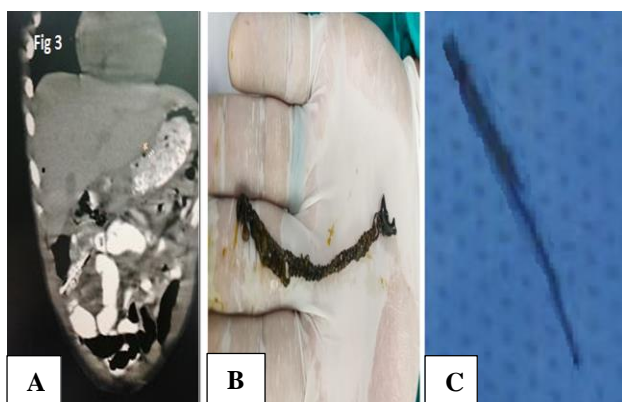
(A) Intra-abdominal FBs in the CT scan; (B) necklace after extraction from intestine; and (C) sharp needle after extraction from urinary bladder wall.
